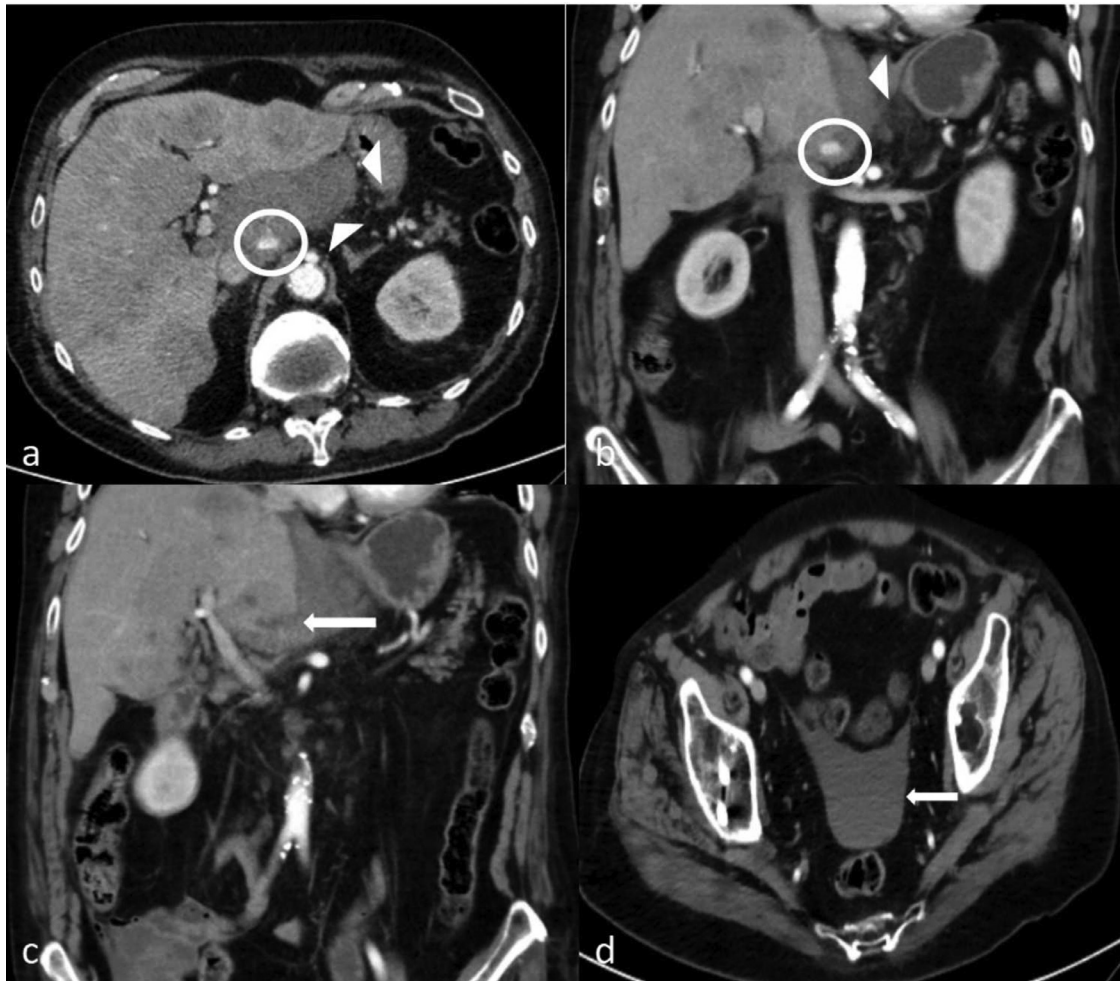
Axial (A) and coronal (B) contrast-enhanced CT images show active contrast extravasation (circles) and hematoma (arrowheads) on the arterial phase suggesting the rupture of metastases in the caudate lobe (C) Coronal contrast-enhanced CT image show the discontinuity of ruptured liver capsule (white arrow) (D) Axial CT image shows free fluid in the pelvis (arrowhead).
